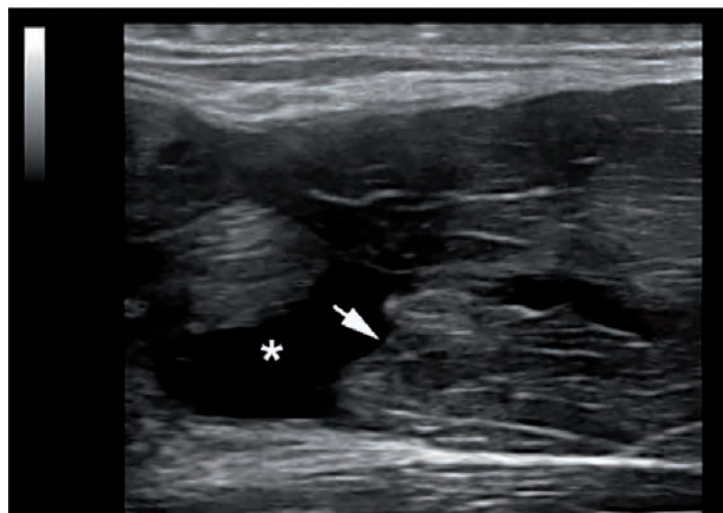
Ultrasonography of the pectoralis major muscle with a lesion. Asterisk – Effusion secondary to the hemorrhage, arrow – The pectoralis muscle blunt (“bell tongue” aspect).
